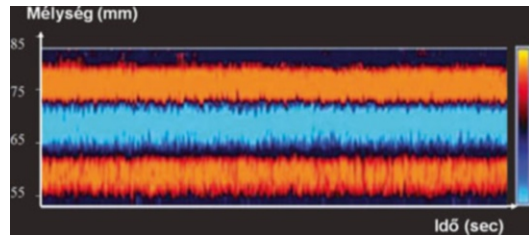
Transcranial Power Motion Doppler (PMD). Three spectrums are seen in the figure at the same time. The lower red band indicates the flow towards the transducer in the ipsilateral median cerebral artery in 55–60 mm depth. The middle blue band indicates the flow in the ipsilateral anterior cerebral artery directed away from the transducer in approximately 65–70 mm depth, while the upper red band represents the flow towards the transducer in the contralateral anterior cerebral artery in about 70–80 mm depth
